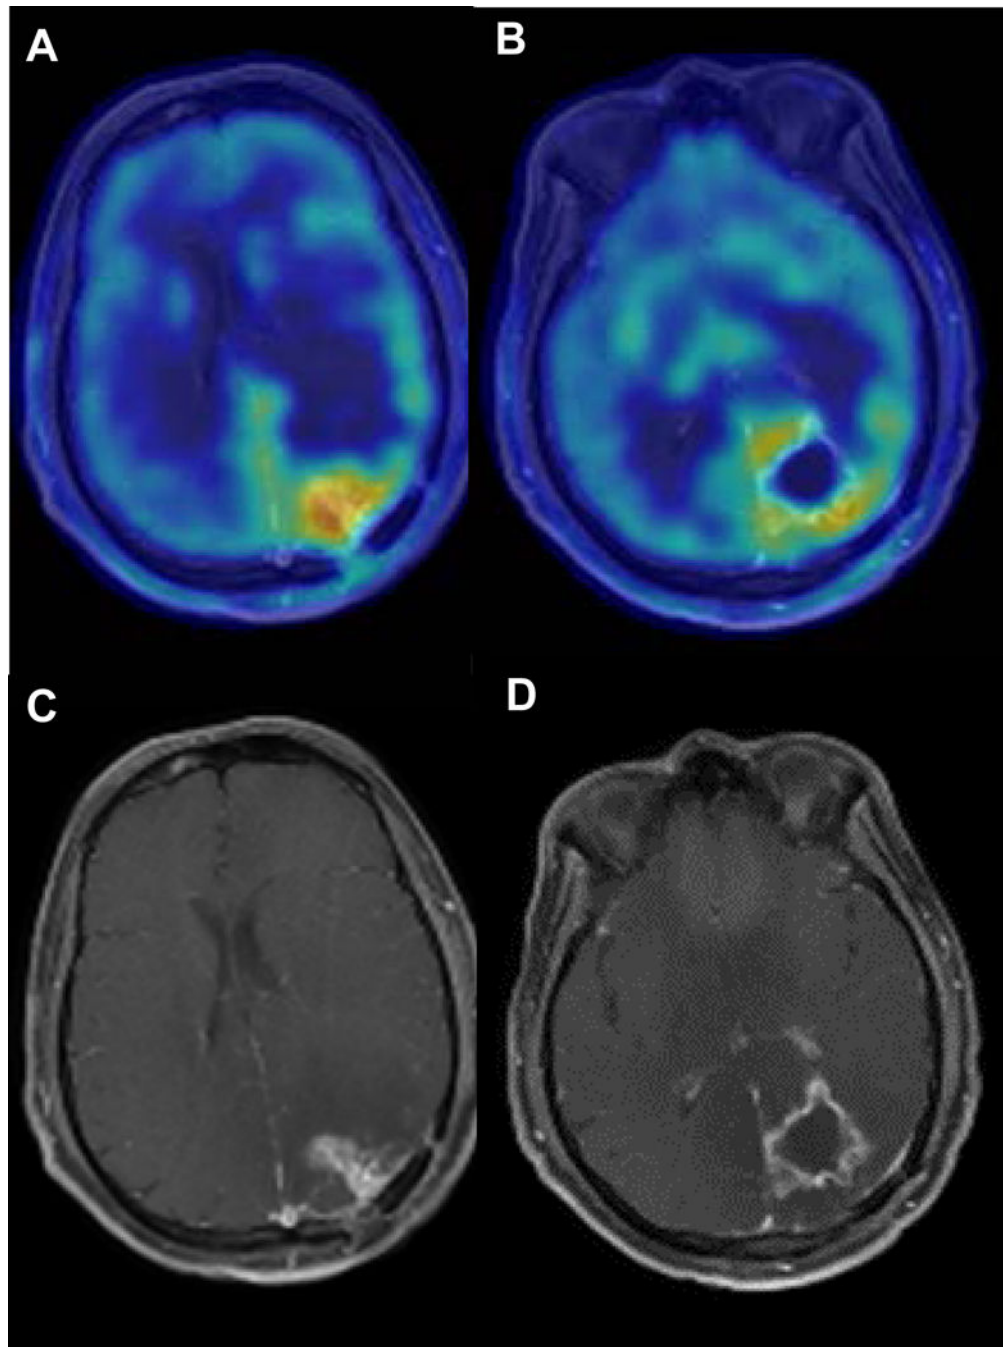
Axial T1 post-contrast MRI and AMT-PET imaging for patient 3. Pretreatment imaging demonstrated AMT SUV ratios slightly above 1.65 in various tumor regions, consistent with active tumor and similar to baseline values seen in patient 1. No repeat AMT-PET was done due to rapid clinical progression during the first cycle of indoximod treatment.
